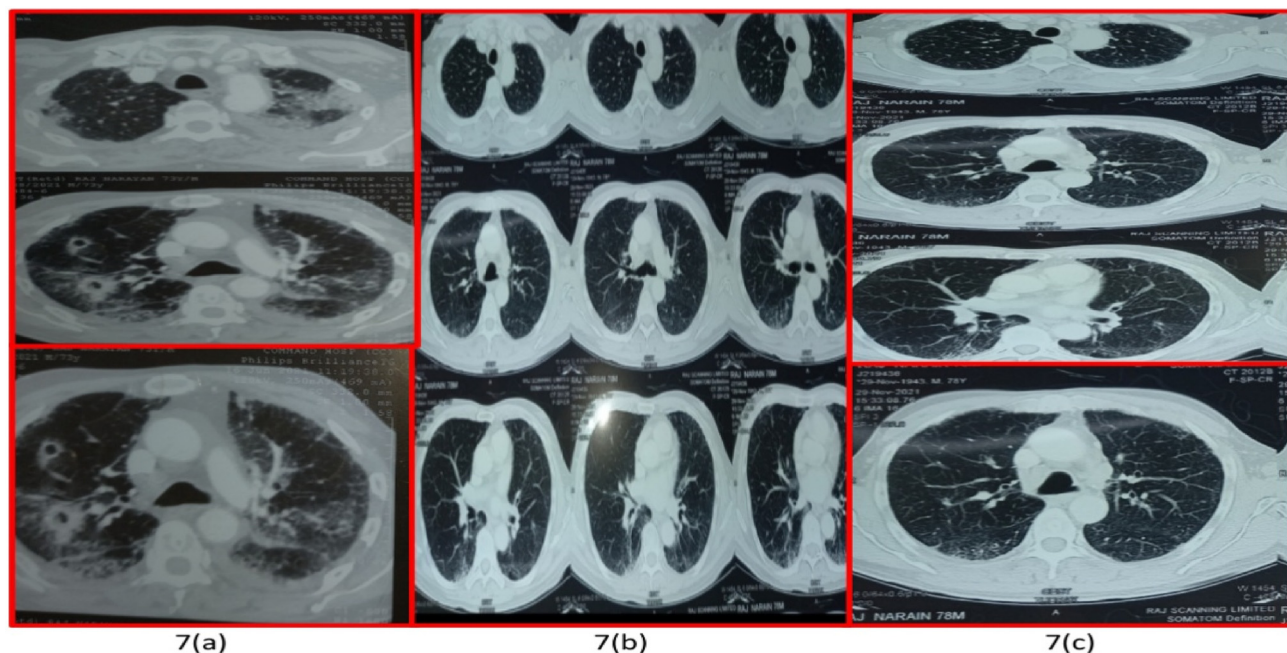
Patient no 2, known case of rheumatic heart disease with post-COVID fungal pneumonia. (a) CT chest showing cavity RUL. (b) Follow-up CT after 3 months showing significant resolution of disease.
